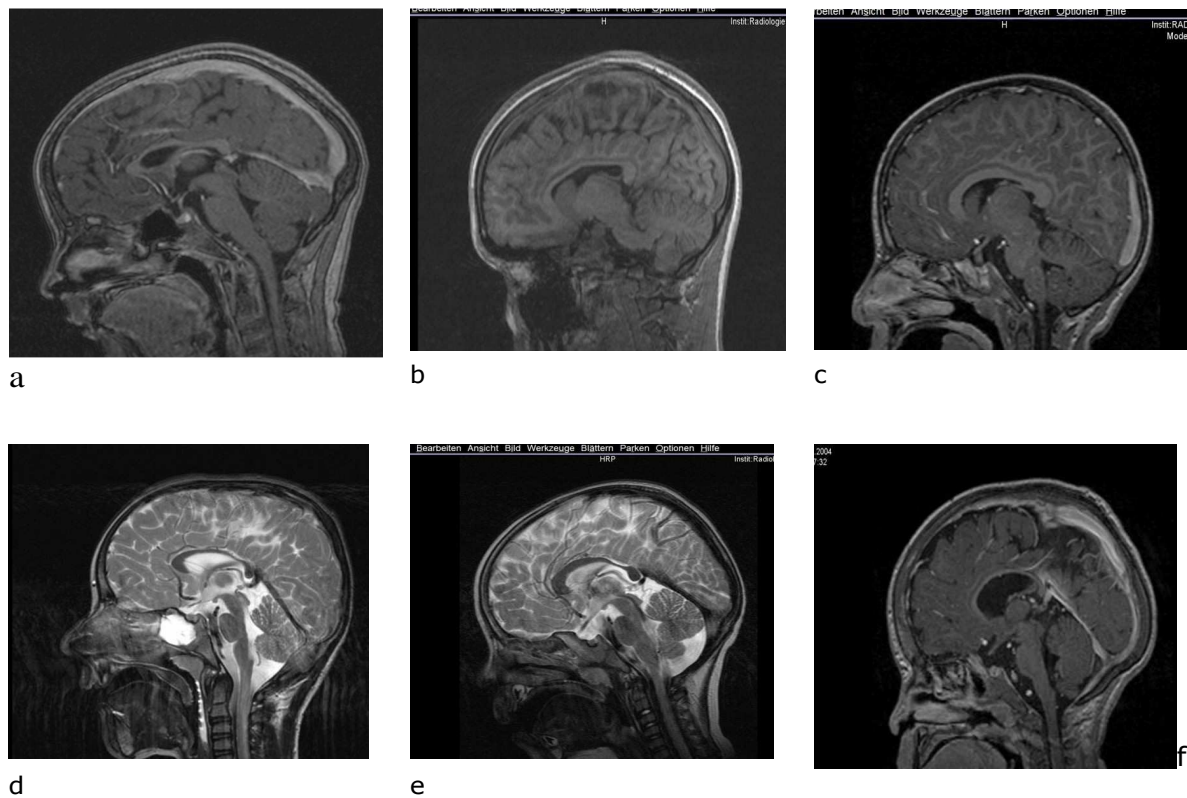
MRI show location of thinnest part of corpus callosum. a.: 11 years old girl with GMFCS I, she was a premature infant at 36 weeks. Note that the thinning of CC is at rostral body. b.: 15 years old girl with CP GMFCS level III, she was born at 32 weeks, she has also speech delay. Note that the thinning of the CC is at posterior midbody. c: 10 years old girl with GMFCS I, she was premature 29 weeks. Note the thinning of the CC at isthmus. d: 14 years old girl with CP GMFCS level IV, she was 31 weeks preterm infants, the thinning of CC is at the posterior midbody and isthmus. e: 5 years old boy with CP GMFCS level I, he was premature infants at 33 weeks, note that the thinning of the CC located at Isthmus, posterior midbody and splenium. f: 15 months old boy with CP GMFCS level IV, he was twins 34 weeks. Note that the thinning of CC is global.
